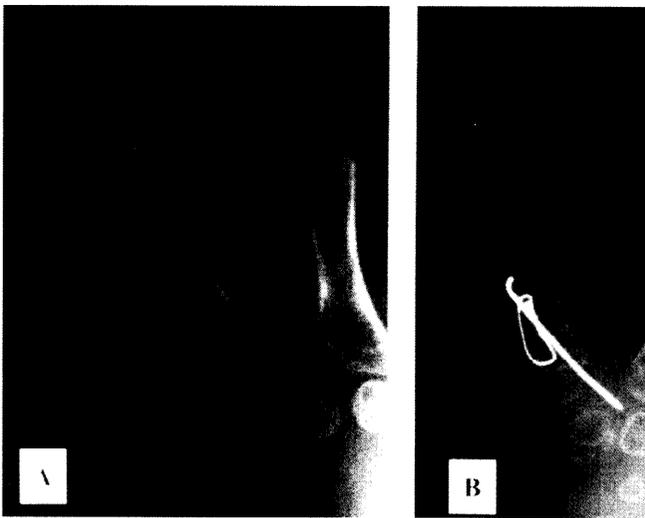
Radiographs showing intact skeletal structures (A). The derotation osteotomy was fixed with a Kirschner wire and an interosseous wire (B).
